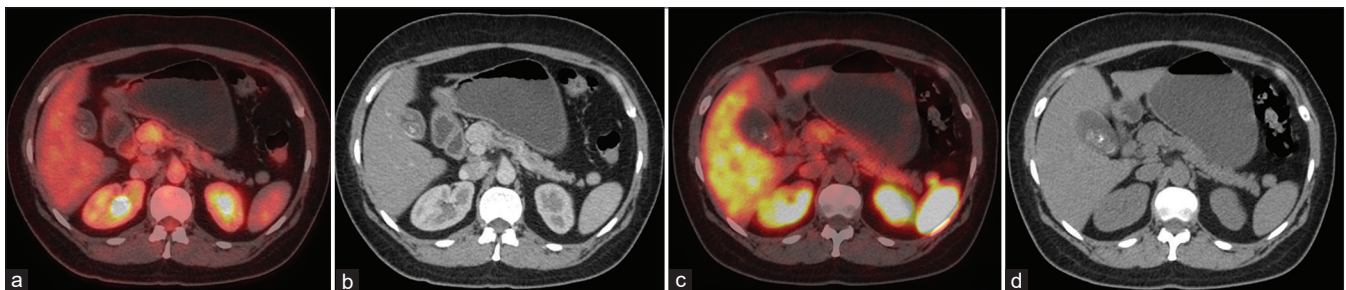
Case of a 45-year-old female, who was a diagnosed case of Neuro-endocrine tumors grade 2. The patient underwent 18F-FDG Positron emission tomography/computed tomography (Trans-axial Positron emission tomography/computed tomography [a] and computed tomography [b]), which revealed a mass in the head of the pancreas, with moderately elevated 18F-FDG uptake. The patient also underwent 68Ga-DOTANOC Positron emission tomography/computed tomography for treatment planning (Trans-axial Positron emission tomography/computed tomography [c] and computed tomography [d]), which also revealed mild-moderate activity in the mass lesion. Higher 18F-FDG uptake in this patient compared to 68Ga-DOTANOC (P4 in NETPET score) meant more aggressive phenotype and lower survival
